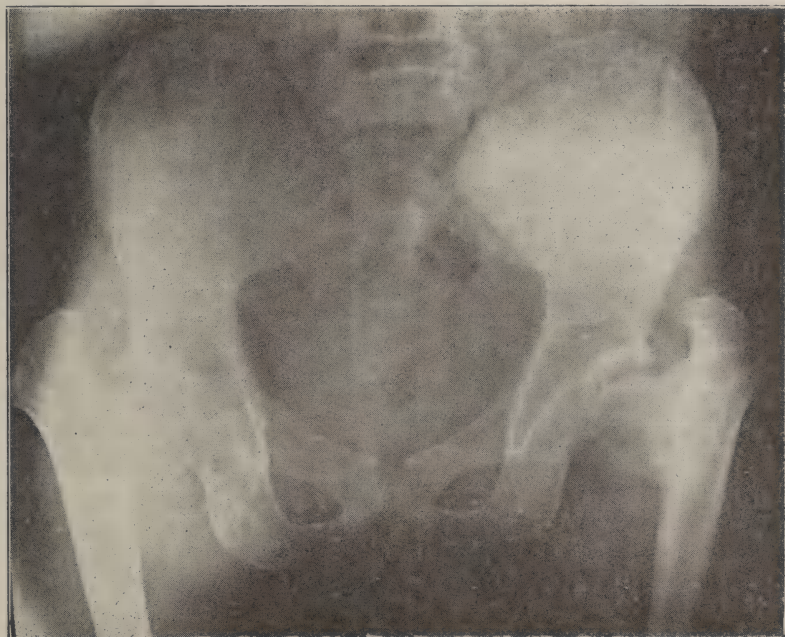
Radiography from the pelvis, showing the coxa vara.
